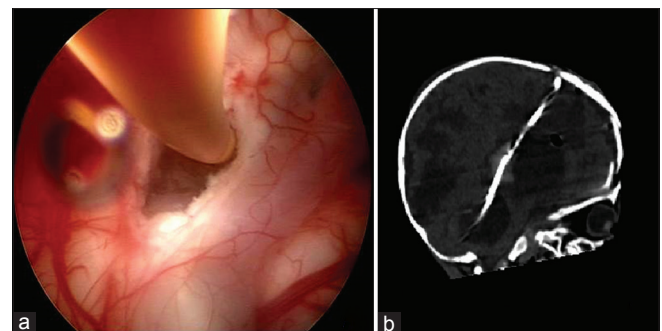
(a) Intraoperative photograph: the endoscope is inside a cyst of the right hemisphere. The perforated rear wall of the cyst through which the silicone catheter goes into IV ventricle is seen. (b) The postoperative computed tomography of the brain shows the stent which drains IV ventricle and cyst
